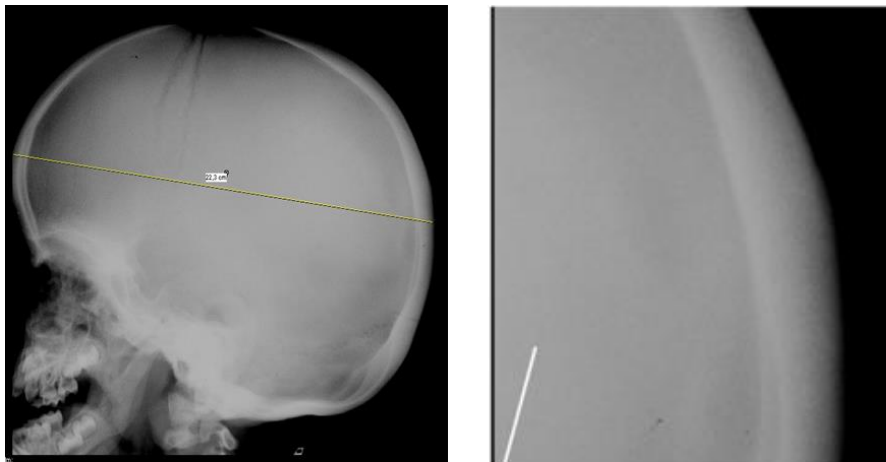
Lateral x-ray of the skull showing enlarged neurocranium in ap diameter (22.3 cm) with thick calvarium especially of the posterior two-thirds of the skull vault (short arrow). Pituitary fossa (long arrow) is elongated ventrodorsally into an omega-shape due to long recesses under the anterior clinoid processes. Underdevelopment of the paranasal sinuses and progenia due to the enlarged mandible and square condyles are present.
